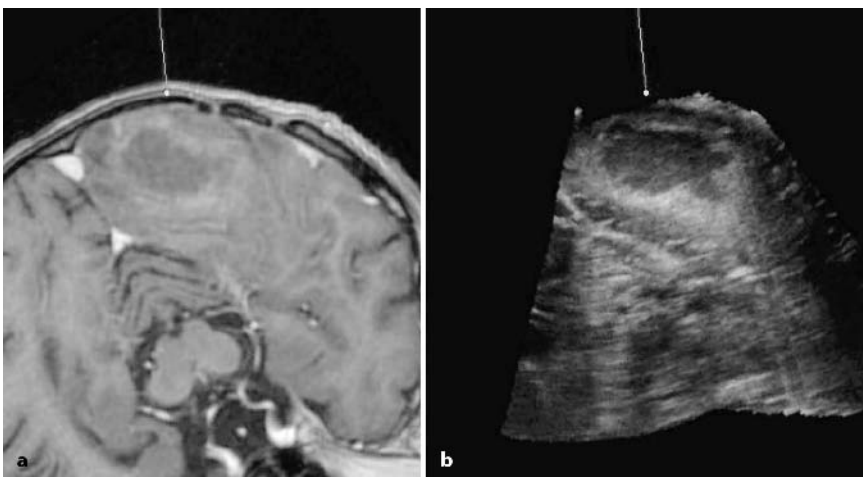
Image-guided planning of the operative trajectory to avoid critical areas, e.g., optic radiation. Online visualization of preoperative MR (a) and intraoperative ultrasound images (b) allows compensation for brain shift during resection of the cystic metastasis
